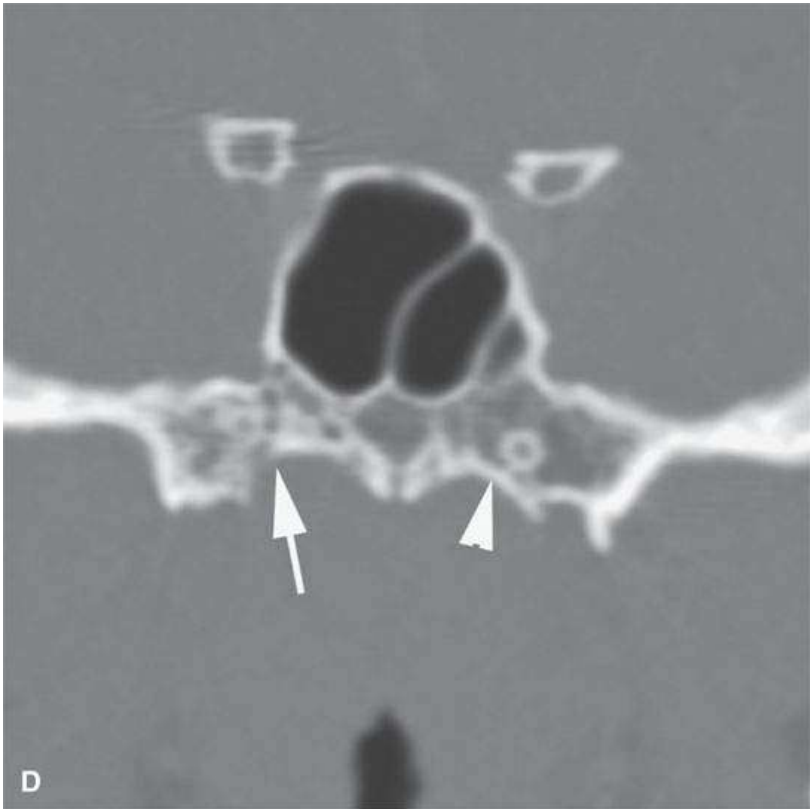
Contrast-enhanced magnetic resonance demonstrating early infiltrating lymphoma of the nasopharynx. A: Contrast-enhanced T1-weighted (T1W) image shows early infiltration of the parapharyngeal fat and palatal musculature (*arrowheads*) that border the nasopharynx, suggesting early clival invasion (*arrow*). B: T2-weighted image correlating with (A) confirms those findings. C: Non-contrast-enhanced T1W image suggest early clival erosions (*arrow*). D: Computed tomography confirms early cortical bone erosion just to the right of midline (*arrow*) compared to the normal cortex just to the left of midline (*arrowhead*).
